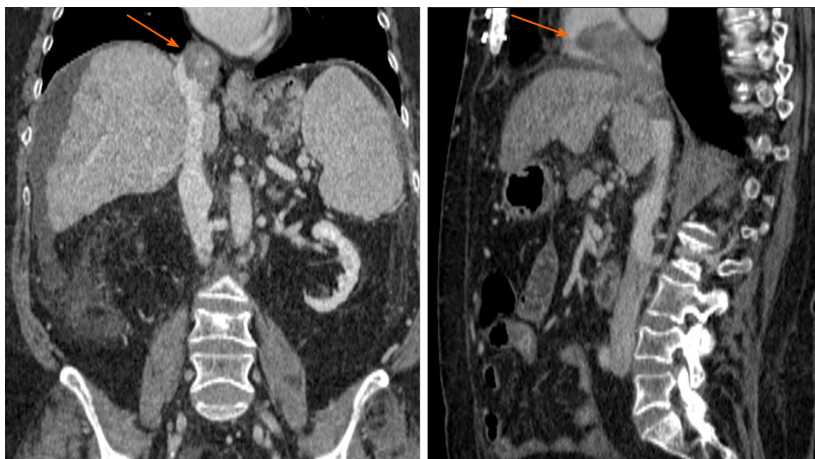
Computed tomography scan coronal and sagittal views show a 55 mm × 90 mm mass in segment VIII with a tumor thrombus extending to the inferior vena cava (left arrow) and reaching up to right atrium (right arrow). Left intrahepatic portal thrombosis. Portal vein thrombosis with hypercaptation of the thrombus, suggestive of infiltrative tumor.
